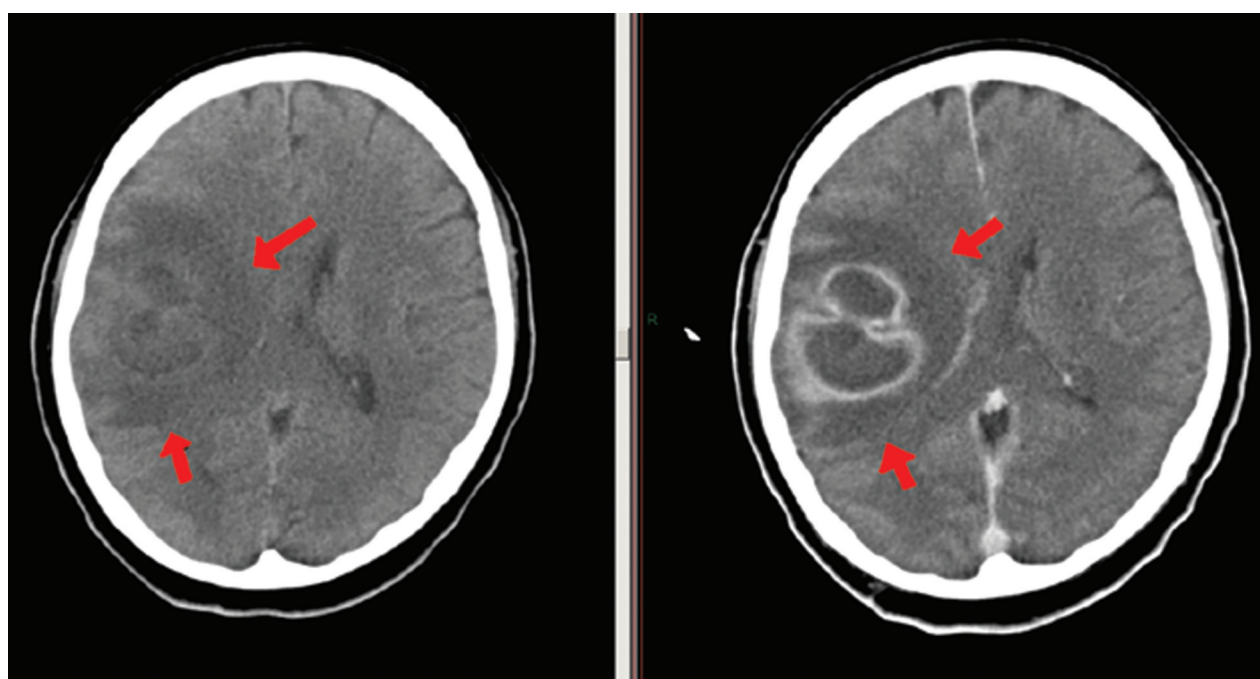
CT of brain, on the left without contrast and on the right contrast enhanced, showing large temporo-parieto-frontal abscess with mass effect (arrows).
